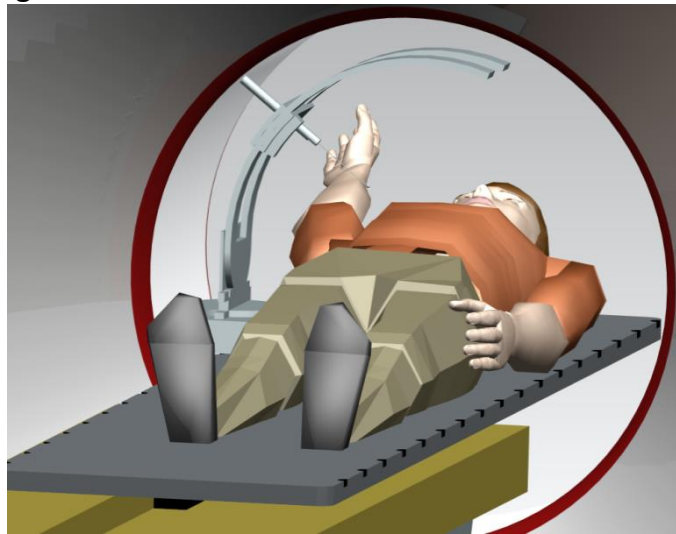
Detail showing the ATEN robot position inside the CT-Sim gantry
